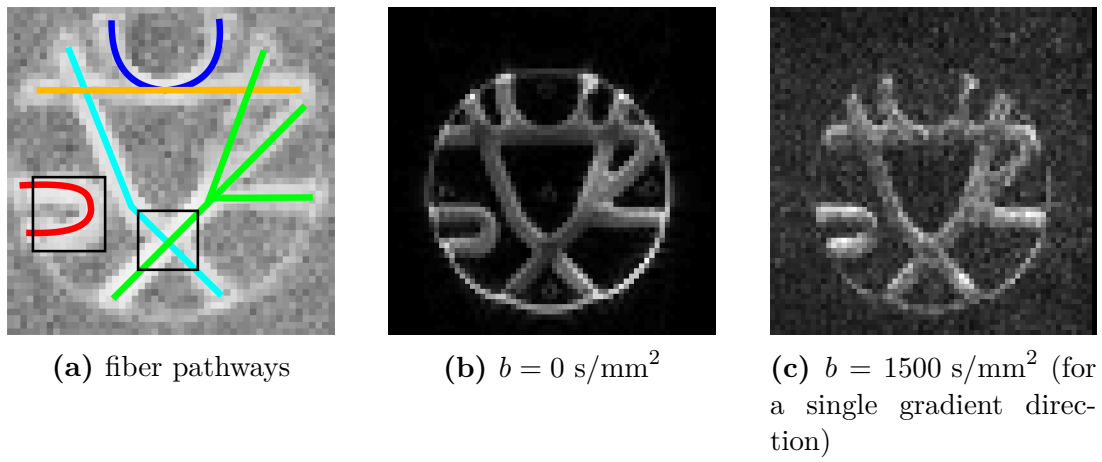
Fiber pathways (*left*) and Diffusion MRI acquisition (*middle and right*) for one slice in the $x - y$ -plane.
